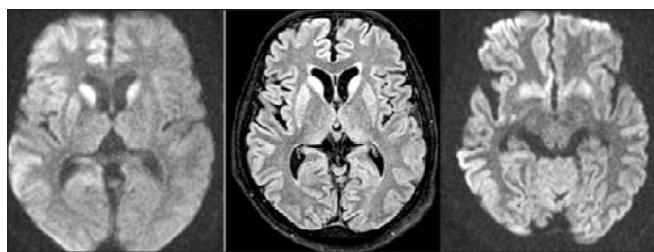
Patient E. brain MRI shows the hyperintensity in the caudate nuclei (FLAIR, DWI sequences) and pulvinar thalamic nuclei (FLAIR) that is called a Tdouble hockey stick sign. DWI sequence identifies hyperintensity of the right hemisphere cortex (the cortical ribbon sign).
